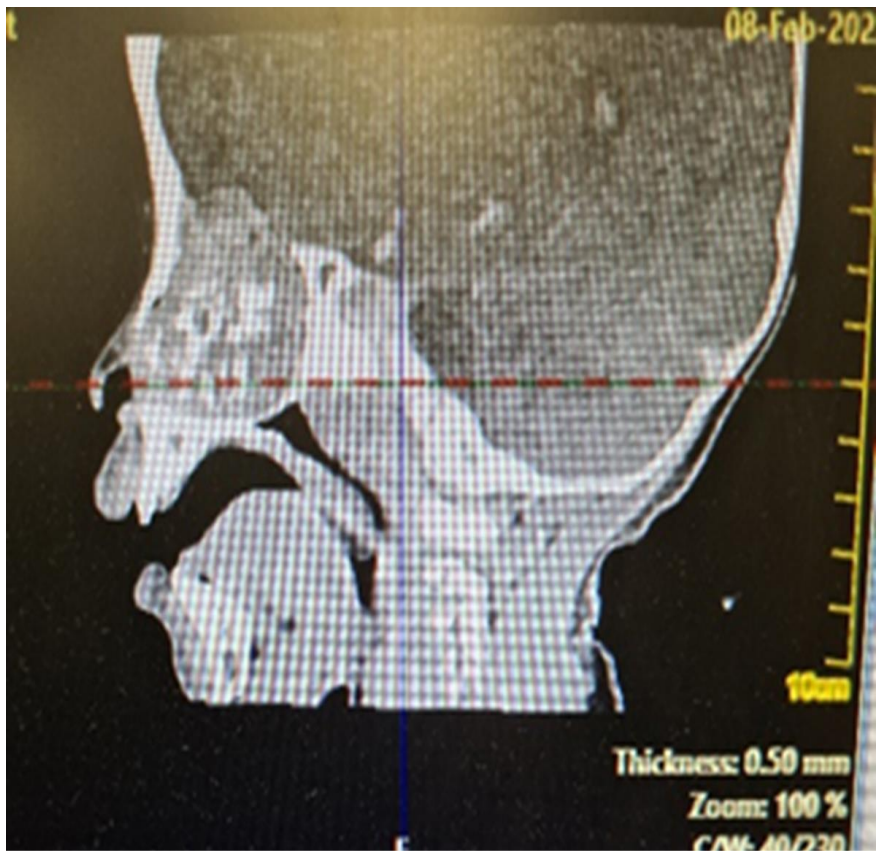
Post-op CT Scan of the paranasal sinuses and the brain (axial view)
